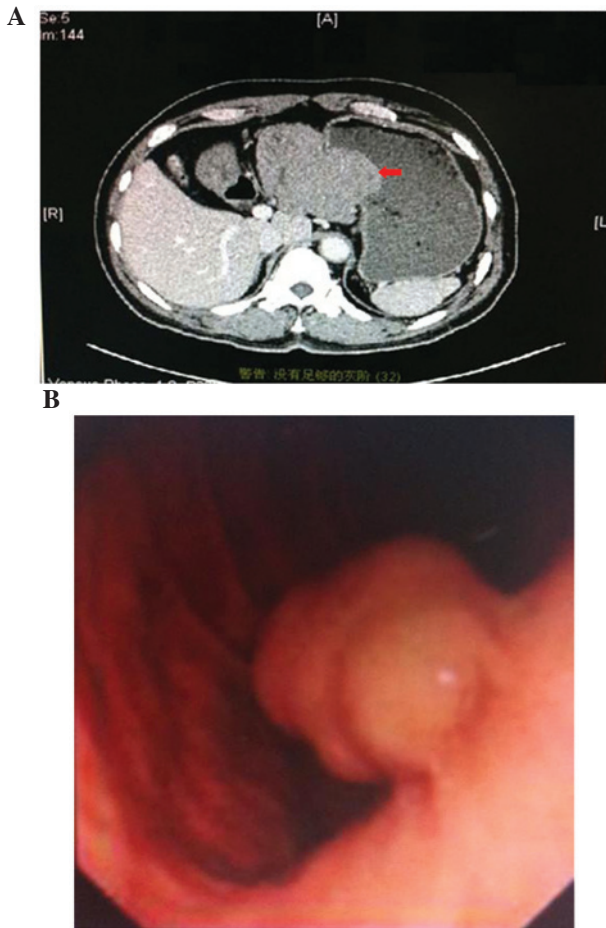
(A) Computed tomography revealed a giant mass (arrows) located in the lesser curvature of the stomach. (B) Macroscopic findings of the gastroscopy revealed a giant mass.
